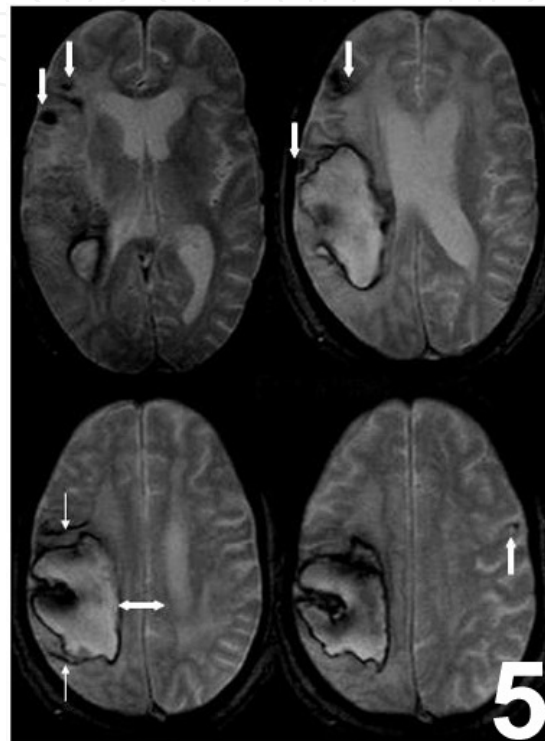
T2*-weighted gradient-echo MR image of same patient as in figure 1, shows two linear areas of signal void (thin arrows) in the vicinity of large primary lobar hemorrhage (thick arrow) suggest chronic subarachnoid hemorrhage and cortical superficial hemosiderosis.
